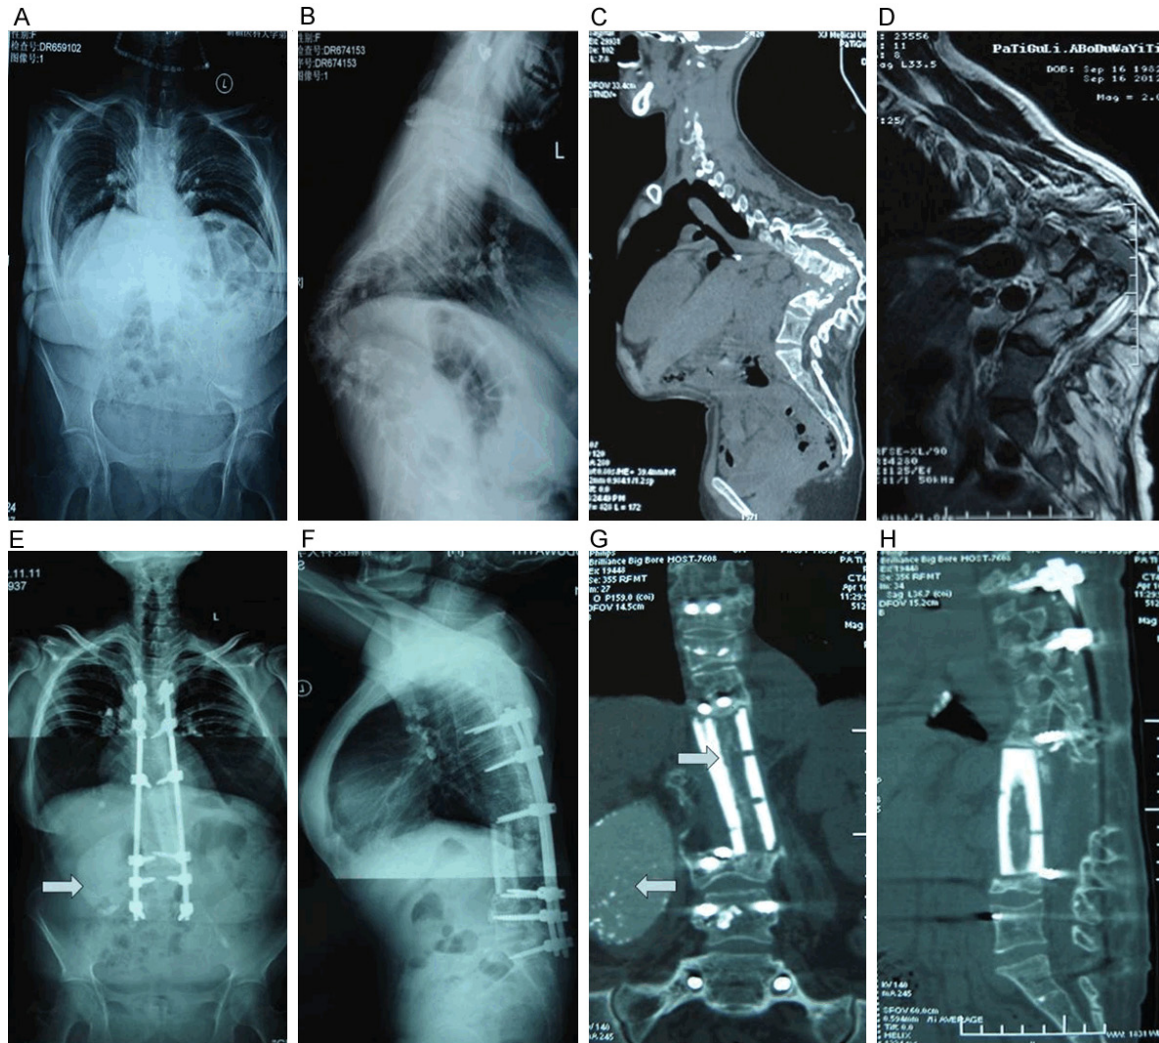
Pre- and postoperative imaging of the patient shown in Figure 1. A, B. Preoperative anteroposterior and lateral, respectively, computed tomography (CT). C, D. Preoperative anteroposterior and lateral, respectively, magnetic resonance imaging (MRI). E, F. Postoperative anteroposterior and lateral, respectively, CT showed a complete correction of kyphosis. Arrow in E indicates a huge abscess around the right psoas. G. At the 1-year follow-up, CT showed the bone cage with a continuous bone callus as indicated by the top arrow and the right psoas abscess was not fully absorbed as indicated by the lower arrow. H. Perfect positioning of the bone grafts was noted at 1-year.
